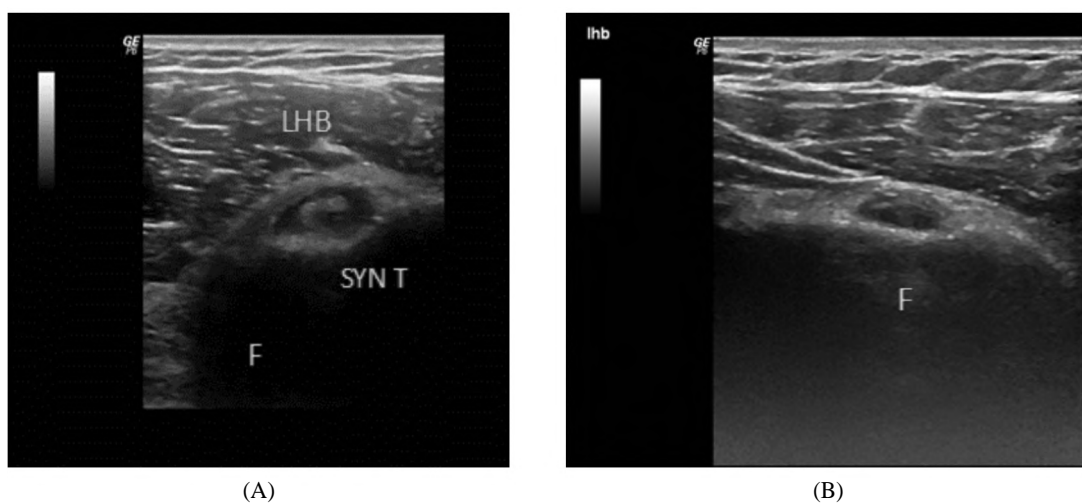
Static B mode ultrasonography TS view (A) Long head of biceps (LHB) tenosynovitis with relative synovial thickening (SYN T) (4mm) (grade 2) and synovial effusion (F). Follow-up static ultrasonography TS view B mode (B) Decreased amount of biceps synovial fluid (F) denoting improvement (grade 1). (N.B: LHB = Long head of biceps).
